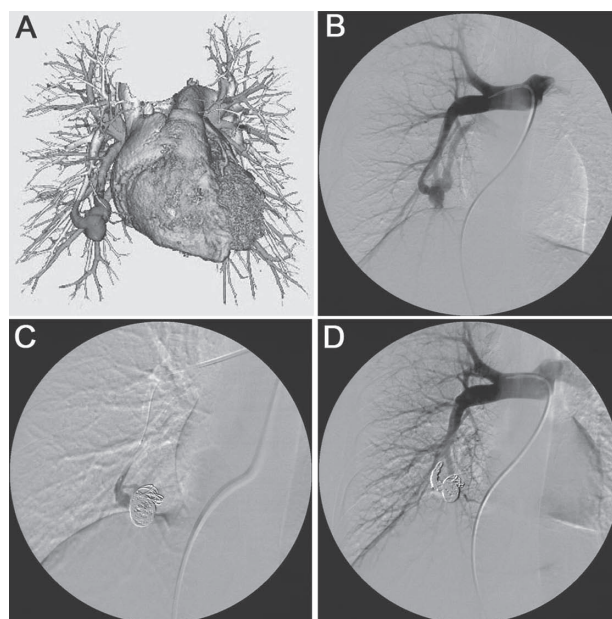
Embolization of a PAVM with a large venous sac and drainage vein of a 34-year-old man. A, B. A PAVM with a venous sac 26 mm in diameter is seen in the right S8 on 3D CT and right pulmonary angiography. C. Embolization of the venous sac with GDCs under flow control with a balloon catheter avoided coil migration via the right-left shunt. D. Embolization of the venous sac and feeding artery was confirmed with pulmonary angiography after the procedure.
